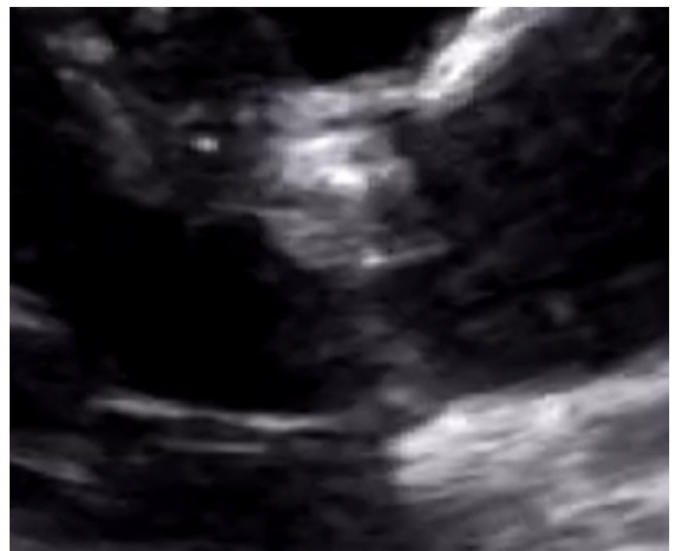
Echocardiogram in the parasternal long axis view showing thickened, echogenic aortic valve cusps. Please note that image was taken from a patient with senile aortic stenosis, however, the thickened, calcified cusps would appear similarly in our fictional patient with bicuspid aortic stenosis. Image courtesy of David Carroll. Carroll D, aortic stenosis (transthoracic echocardiography). Case study, [Radiopaedia.org](https://radiopaedia.org) (Accessed on 02 Oct 2024) <https://doi.org/10.53347/rID-63358> Permalink: <https://radiopaedia.org/articles/89930>, rID:89930.
